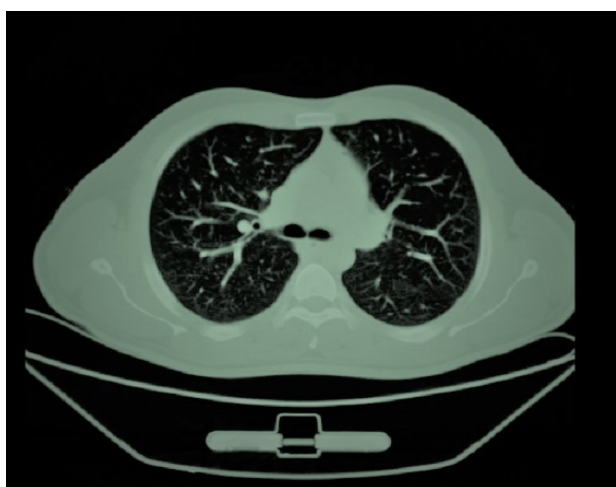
Axial CT of the chest, lung window at the level of upper mediastinum demonstrated resolution of pneumomediastinum.
